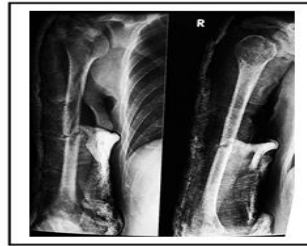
Serial radiographs after 2 months of coaptation splint.
